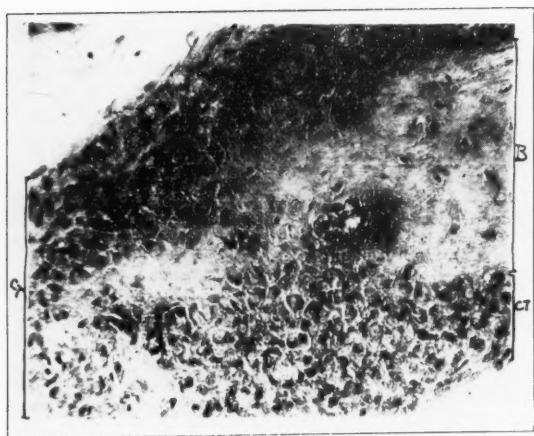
Ethmoid wall ($\times 500$). Young connective tissue cell invasion of normal bone; osteomalacia. B—Bone. CT—Young connective tissue cells.
